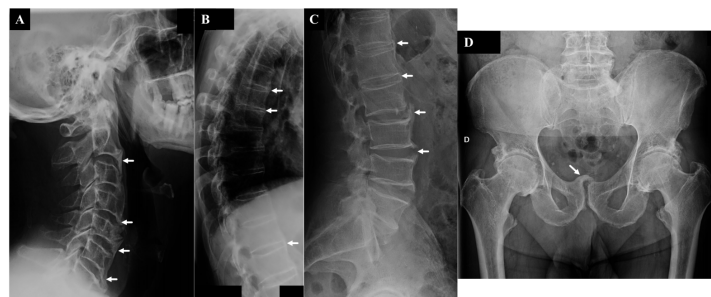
Cervical spine radiography revealing thickening and ossification of anterior longitudinal ligament (arrows) .
